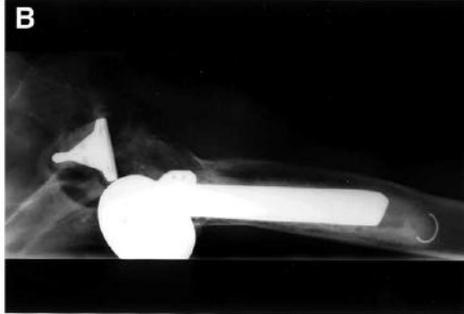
A and B, Preoperative radiographs of a 69-year-old man with a posteriorly dislocated total shoulder arthroplasty. C, Radiograph taken 1 month postoperatively demonstrates a long-stem prosthesis with gaps present at the osteotomy site for the anterior window. The cortical window was repaired with suture and bone-grafted. D and E, Radiographs taken 5 years postoperatively demonstrate healing of the cortical window.
